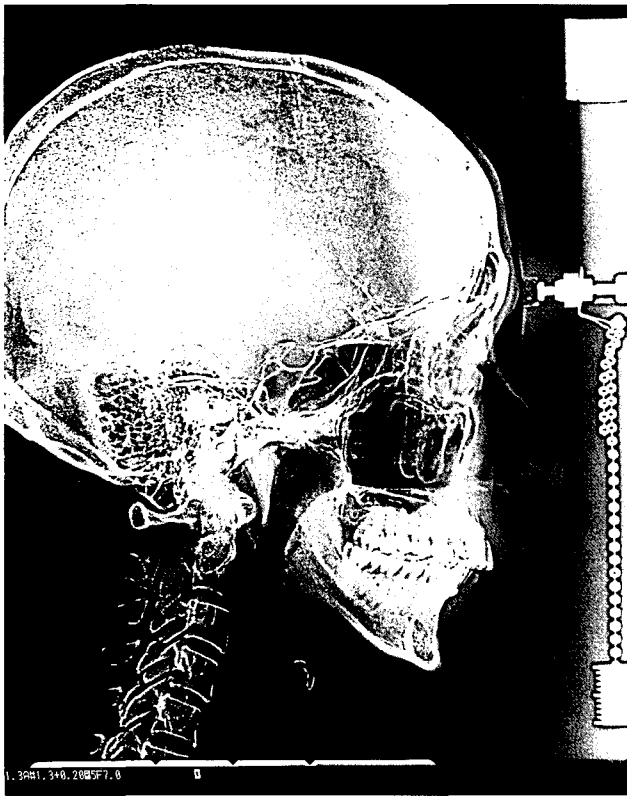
M2 Digital lateral cephalometric radiograph is seen.
